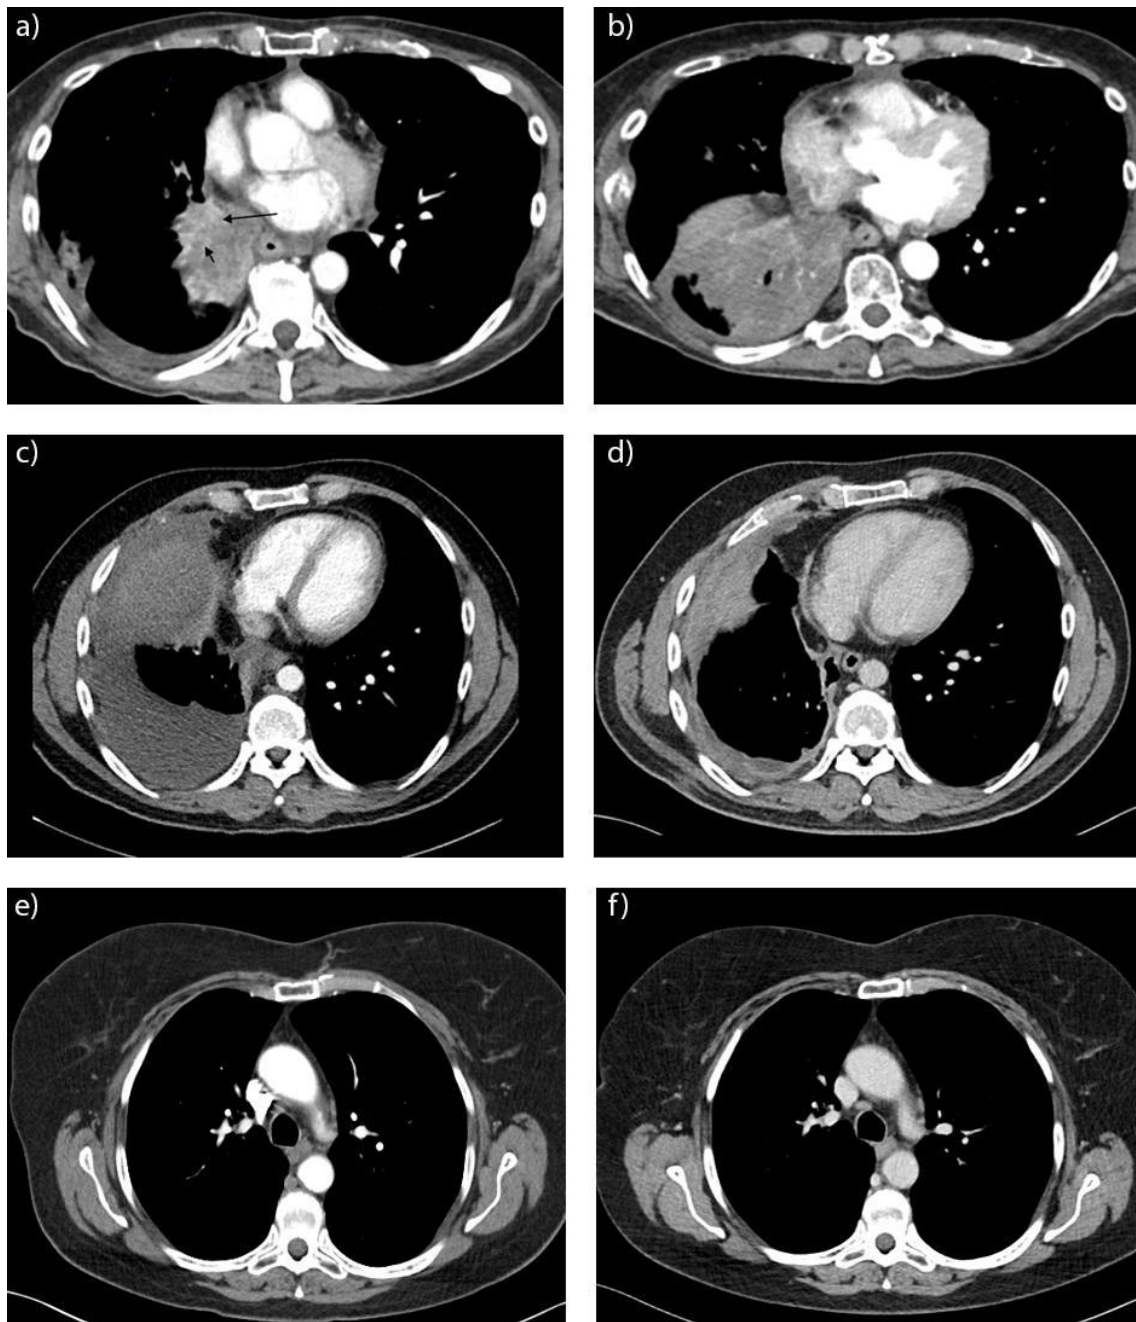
Contrast between arterial and venous phase CTs, with improved visualisation of parenchymal (a, b) and pleural abnormalities. Improved visualisation of nodes from reduced streak and beam artefact is also demonstrated. Venous-phase axial (a) chest CT in soft tissue window of a
